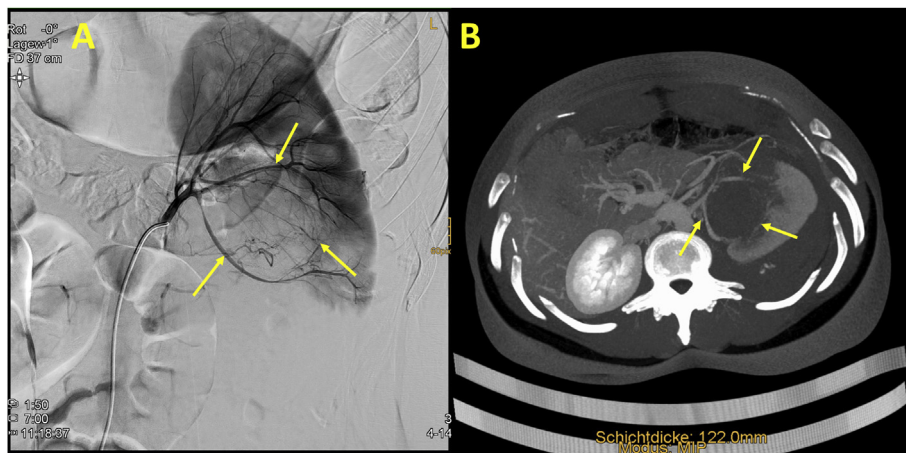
Angiography demonstrating pathological vascular displacement caused by a centrally located mass and pathological tumor vessels (A, arrows). Transversal Maximum Intensity Projection Reconstruction (MIP) of the CT retrospectively showing the displacement as well (B, arrows).
